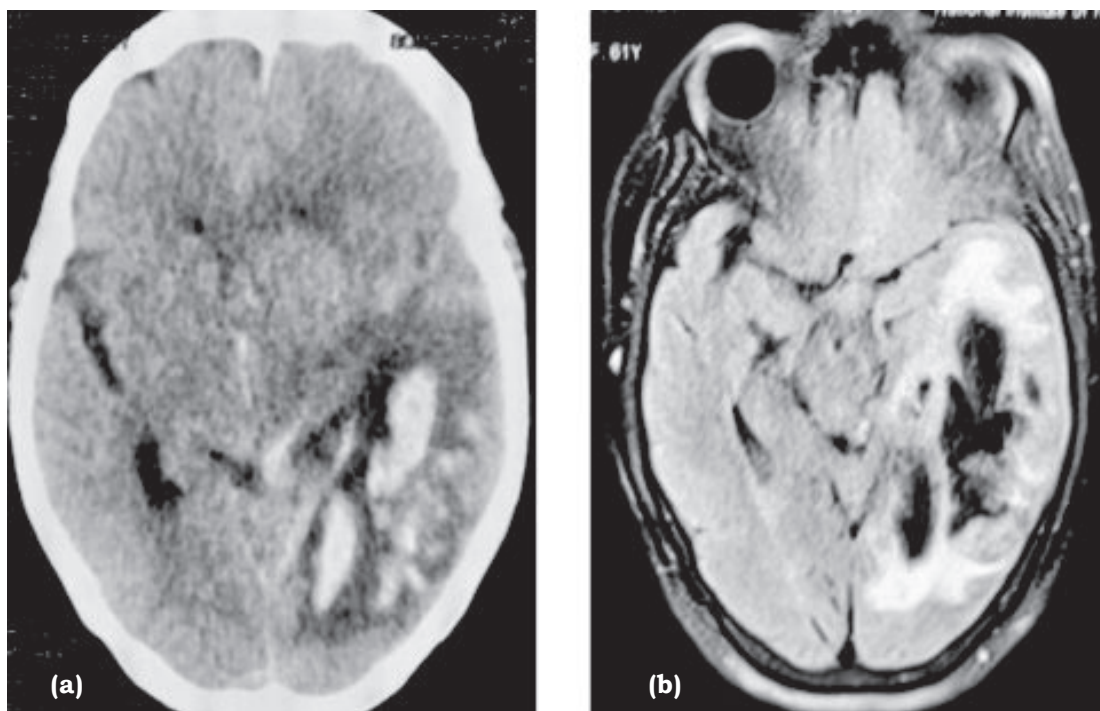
Imaging of the brain, (a) Non-contrast CT scan of the head showed a hemorrhagic infarct left parietotemporal lobe with perilesional edema, (b) MRI brain revealed hemorrhagic infarct in left parietotemporal lobe a uncal herniation.
